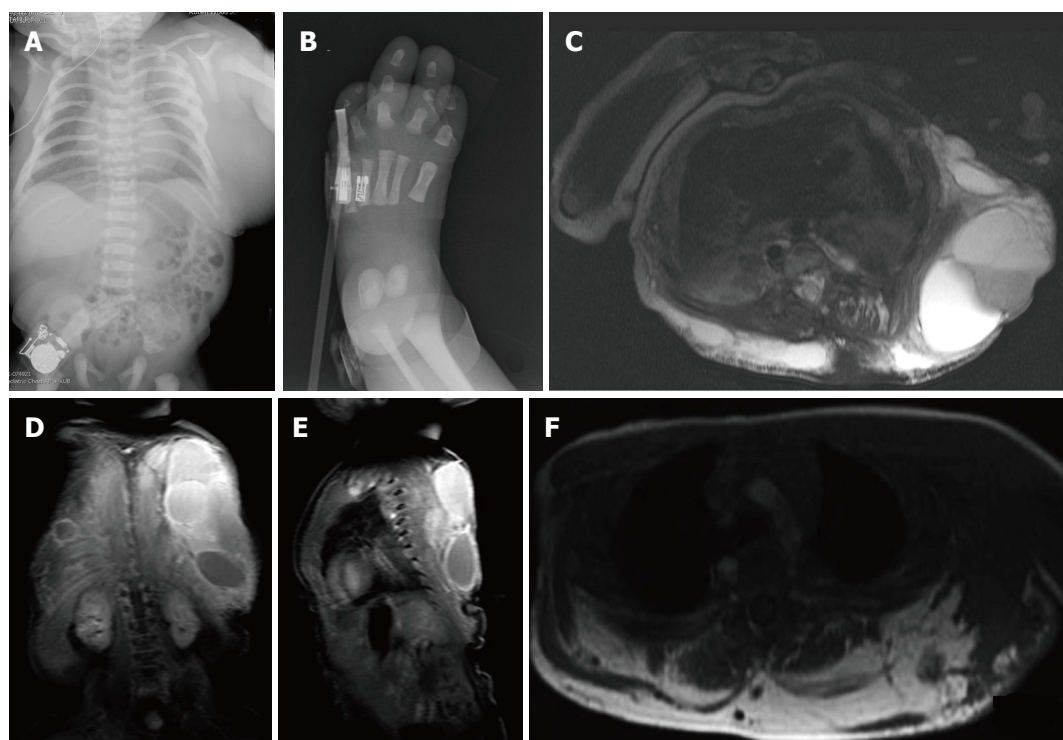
Three-month-old child with CLOVES syndrome. Radiograph of the chest and abdomen (A) demonstrates large soft tissue mass within the left chest and upper abdominal wall. Radiograph of the foot (B) demonstrates overgrowth of the third and fourth digits. Fat suppressed T2 weighted magnetic resonance (MR) images in axial (C), coronal (D) and sagittal (E) planes show the large soft tissue mass within the chest wall contains several loculations, some of which demonstrate hypointense fluid-fluid levels due to hemorrhage. T1 weighted MR image in the axial plane (F) confirms lipomatous overgrowth admixed with muscle.
